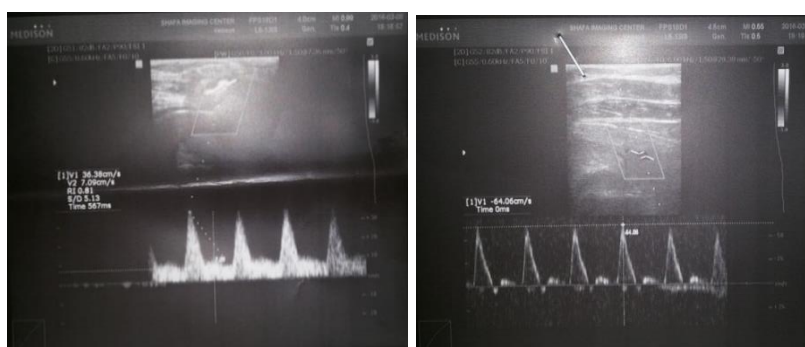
Color Doppler sonography of venous.
